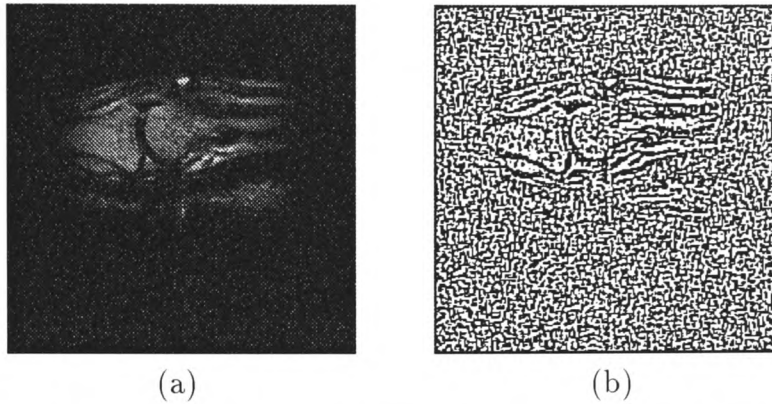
(a) MRI finger scan (b) zero crossings of image showing relatively unclear boundaries.
